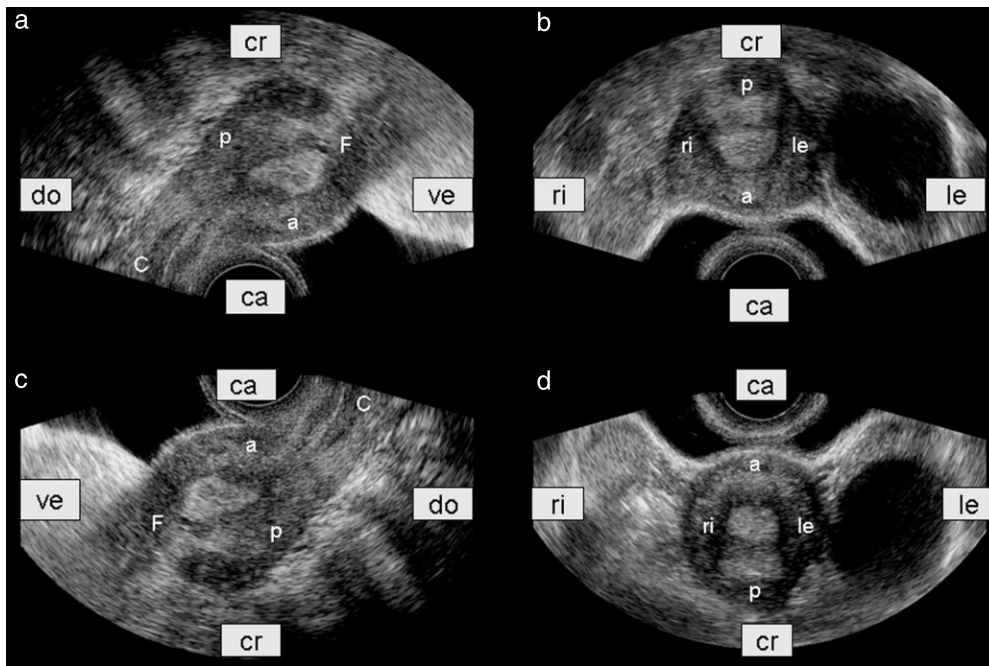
Transvaginal ultrasound images of an anteverted uterus and an ovarian cyst on the left in sagittal and coronal sections of the true pelvis: image displays typical of many European countries (a,b) and of USA, South America and Asia (c,d). The coronal scan through the pelvis shows the anteverted uterus in a transverse section (b,d). Labels in boxes refer to the anatomy of the patient, while labels without boxes refer to that of the uterus. a, anterior wall; C, cervix; ca, caudal; cr, cranial; do, dorsal; F, fundus; le, left; p, posterior wall; ri, right; ve, ventral.
